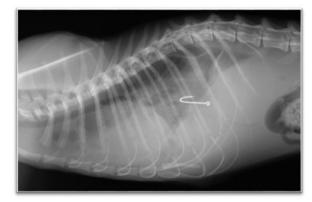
A 2-cm-long fishhook extending from the abdominal cavity to the thoracic cavity via the diaphragm was identified on X-ray
